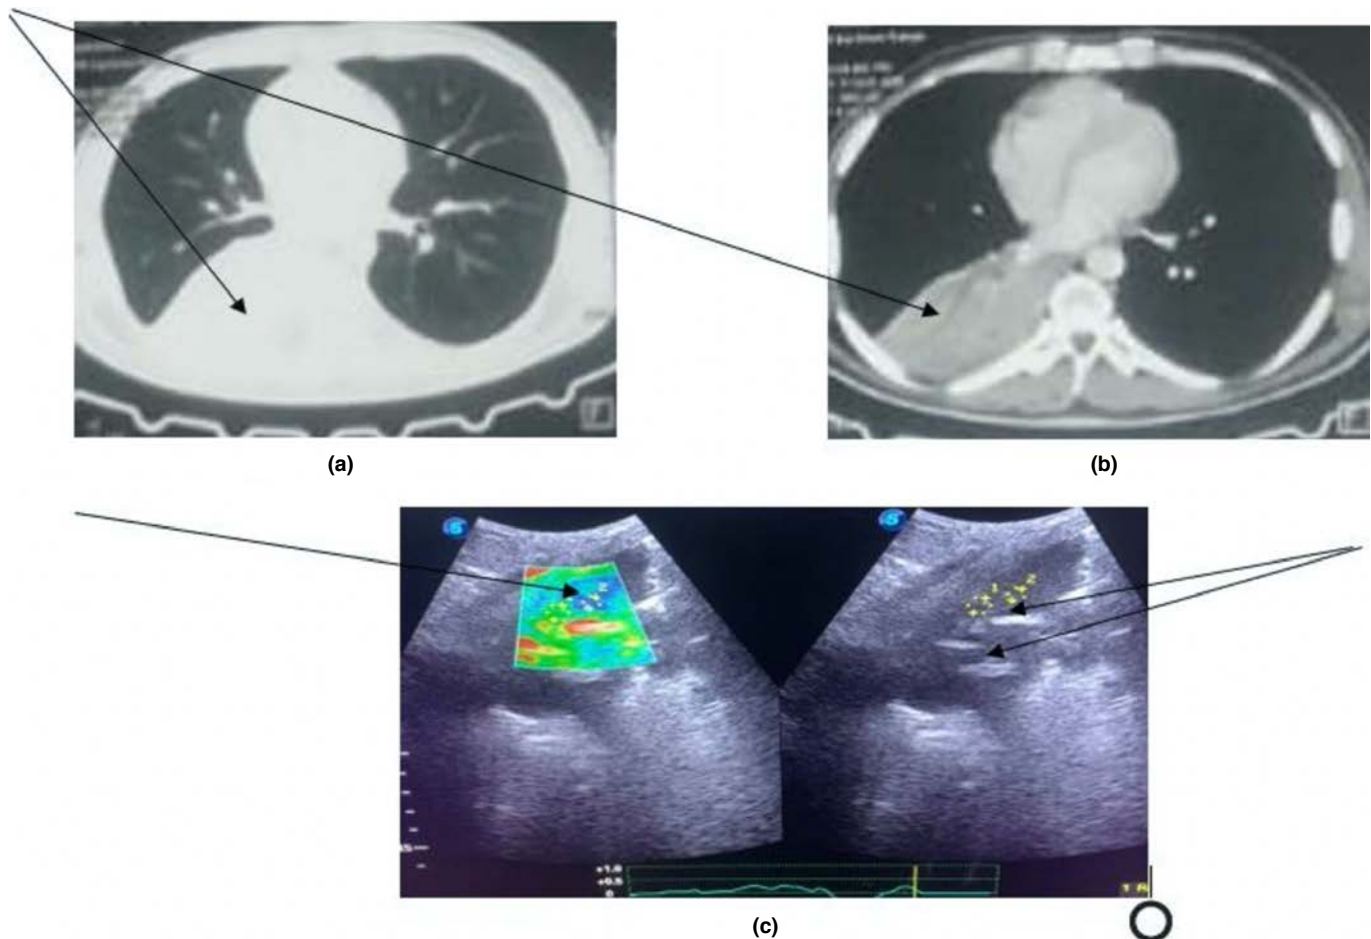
Computed tomography (CT) chest showing right lower lobe atelectasis with corresponding ultrasound elastography examination. (a) CT chest (lung window) and (b) mediastinal window reveal right lower lobe atelectasis. (c) B-mode ultrasound depicts a static air bronchogram, while elastography identifies the lesion as hard, despite the benign nature of the distal atelectasis. This case highlights a false positive in our study, as peripheral atelectasis can exhibit a hard component on elastography despite its benign nature, with a strain ratio (SR) of 1.92
